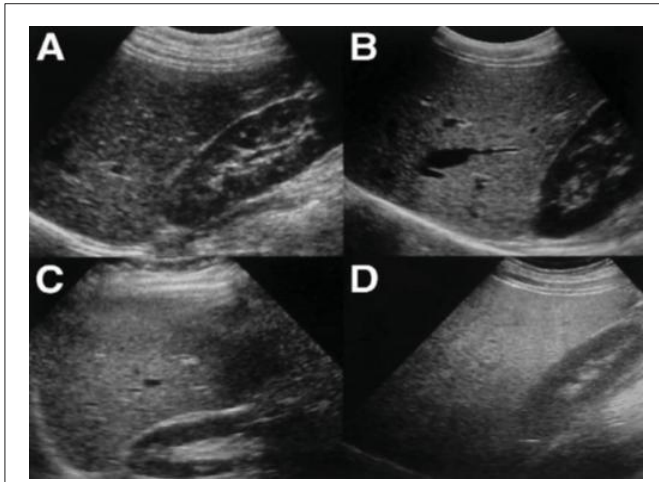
Ultrasonographic criteria for grading of hepatic steatosis.
